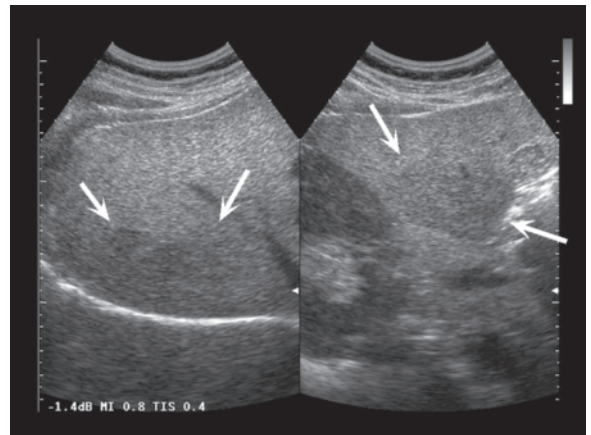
b Focal sparing in steatosis. Patently nodular image with relatively well-defined margins and homogeneous hypoechoic appearance (a). CT scan in the venous phase shows mild hyperattenuation of the lesion, thus ruling out metastasis (b, arrows)
